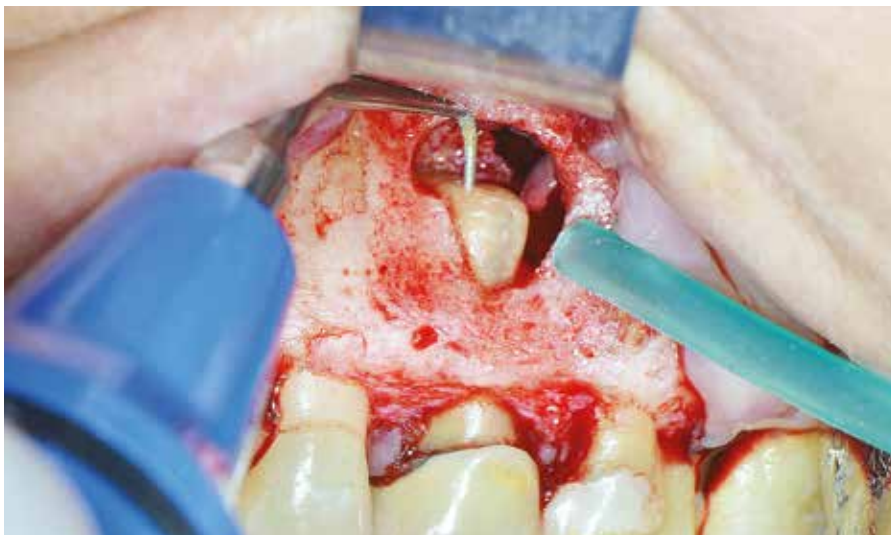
Ultrasonic root end preparation being performed with the ultrasonic tip P1M Helse Ultrasonic (Santa Rosa de Viterbo, Brazil) and irrigation with saline solution.
